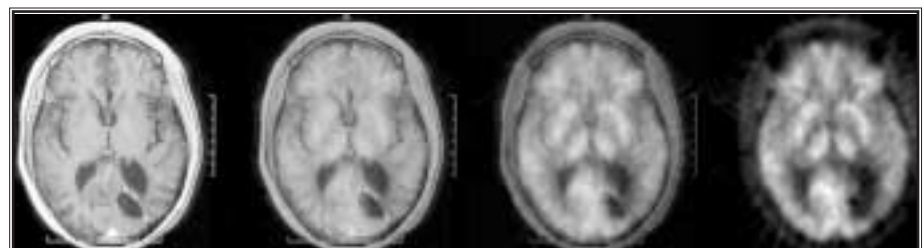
39-year-old man status postresection of left parieto-occipital glioblastoma multiforme followed by chemotherapy and radiation therapy. Contrast-enhanced MR image reveals small areas of enhancement around lesion that are hypometabolic on PET scan. Decreased FDG accumulation is noted in surrounding cortex because this area was in the radiation field.
